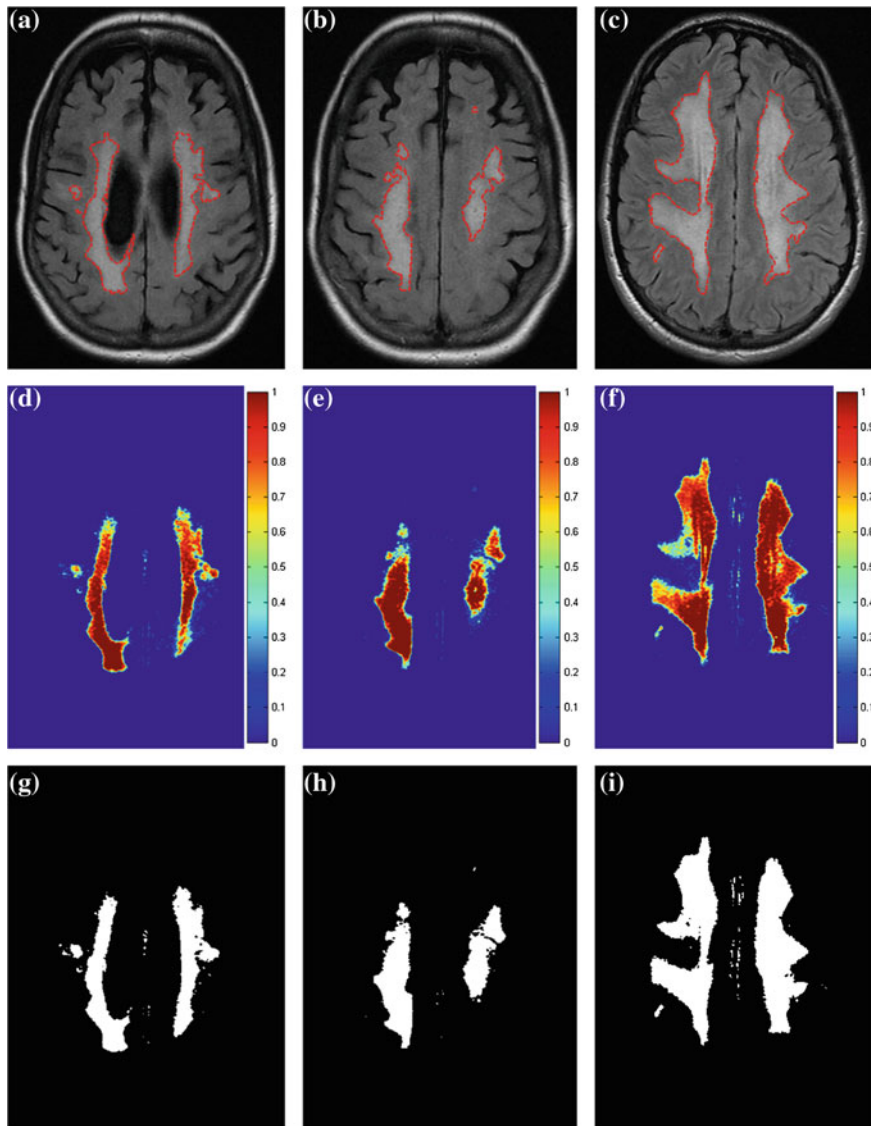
Segmentation of WML in FLAIR MRI. *Top* original images with manual segmentations. *Middle* WML class membership. *Top: Bottom* Thresholded ($\tau^* = 0.15$) and binarized class membership of WML. a Im2. b Im4. c Im22. d ξ_{WML} . e ξ_{WML} . f ξ_{WML} . g $\xi_{WML} > \tau^*$. h $\xi_{WML} > \tau^*$. i $\xi_{WML} > \tau^*$
